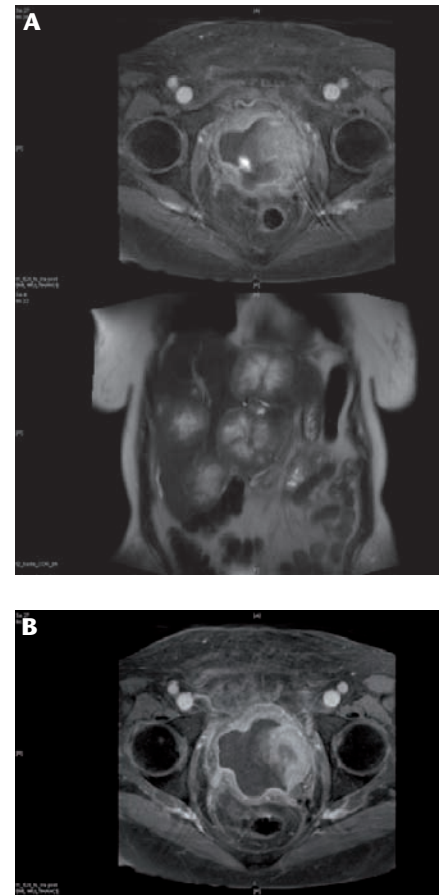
(A) Liver metastases and (B) bladder mass on T2-weighted magnetic resonance imaging.
